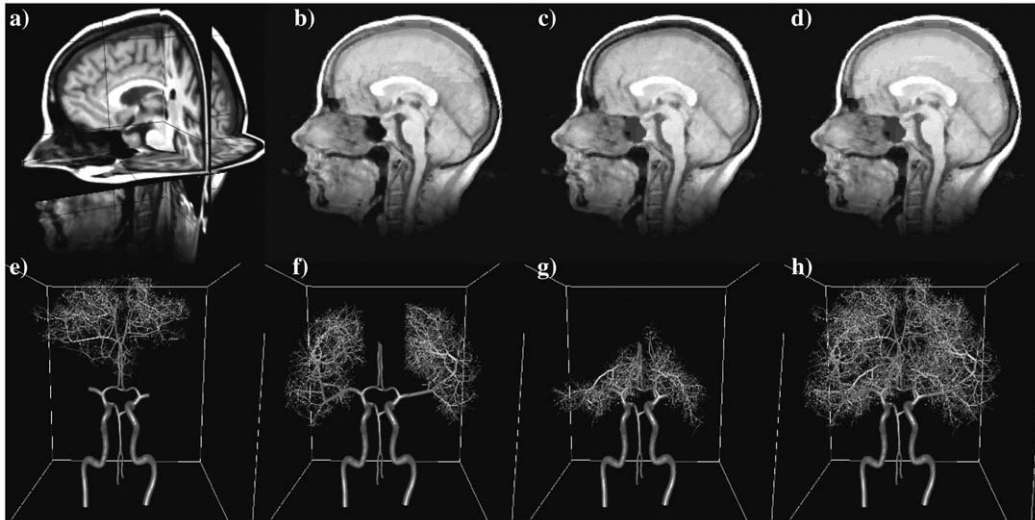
Construction of arterial tree models: a) MRI images of the brain; b) perfusion region of the left ACA; c) perfusion volume of the left MCA; d) superposition of the perfusion regions of the left ACA and MCA; e) tree models for the ACAs; f) tree models for the MCAs; g) tree models for the PCAs; h) tree model for all efferent vessels of the circle of Willis.
